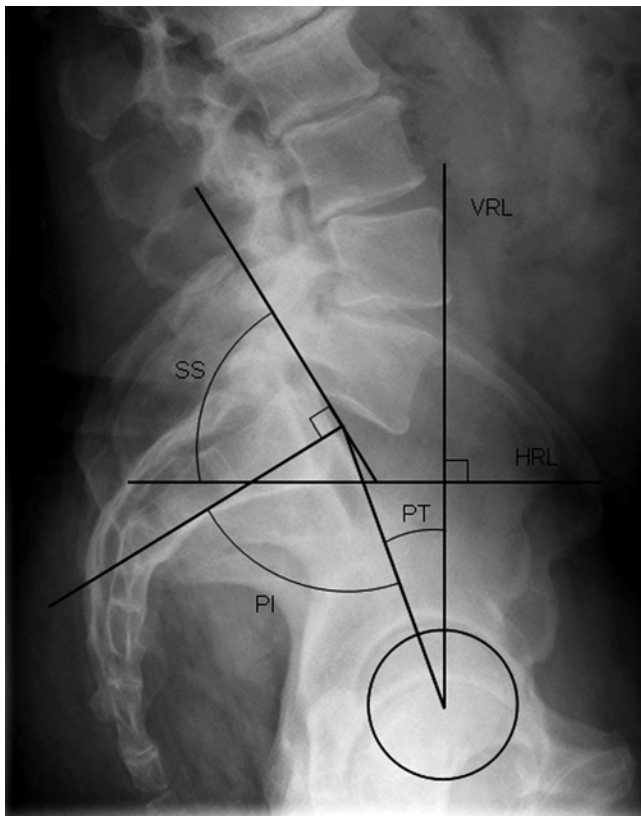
Lateral radiograph of the lumbosacral junction and the demonstrating measurement of important spinopelvic parameters pelvic incidence (PI), pelvic tilt (PT), and sacral slope (SS). These parameters are measured in reference to the horizontal (HRL) and vertical (VRL) reference lines. See Table 29.2 for details of measurement
